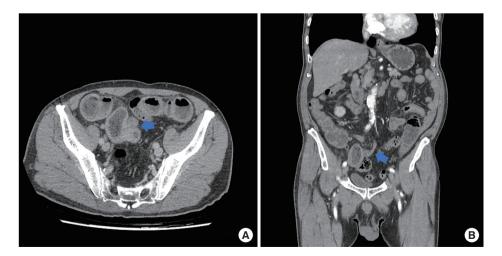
The abdomen CT findings of an 80-year-old male patient who had recurrent SBO without any surgical history. Initial CT scan shows segmental stricture of small bowel and mild distension of proximal small intestine without mass-like lesions (blue arrows) in both axial veiw (A) and coronal veiw (B). This patient was finally diagnosed with small bowel adenocarcinoma postoperatively.
